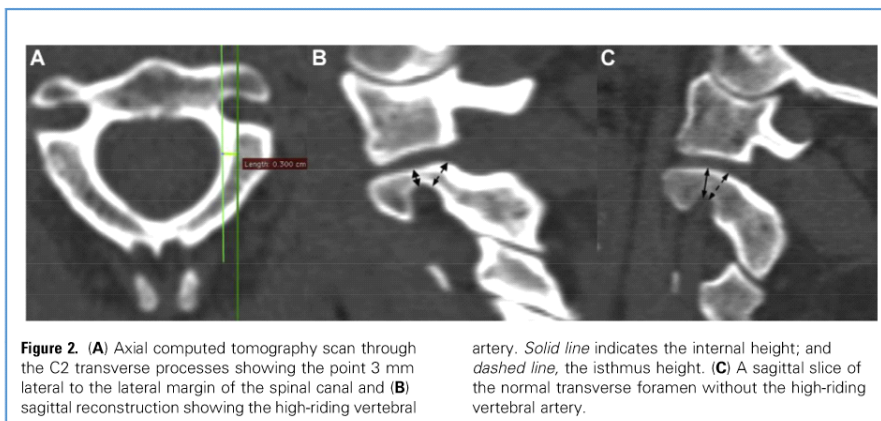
(A) Axial computed tomography scan through the C2 transverse processes showing the point 3 mm lateral to the lateral margin of the spinal canal and (B) sagittal reconstruction showing the high-riding vertebral
